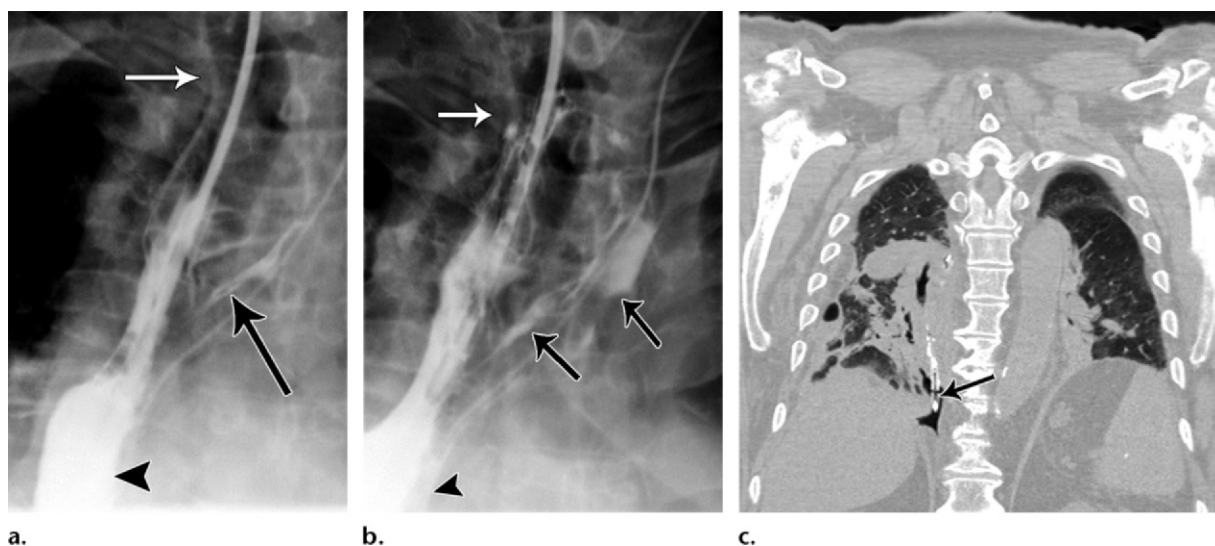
Gastric conduit leak in a 70-year-old man after a transhiatal esophagectomy for adenocarcinoma of the gastroesophageal junction. (a, b) Left posterior oblique esophagrams of the upper thorax obtained on postoperative day 8 show extraluminal contrast agent extravasation (black arrows) from the left portion of the gastric conduit (arrowhead) tracking along the left mediastinal drain. White arrow = cervical anastomosis. (c) Coronal computed tomographic (CT) image (lung window) obtained when the nasogastric tube was advanced shows the tube (arrow) perforating the gastric conduit at a lower level and terminating in the right pleural space. The air surrounding the tip of the nasogastric tube indicates a pneumothorax.
